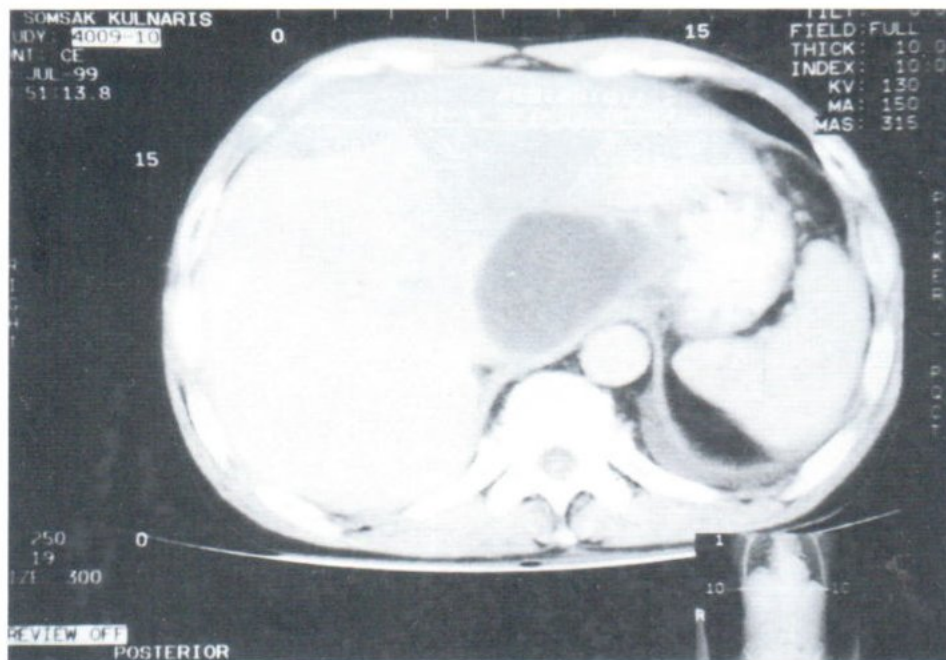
CT scan with IV contrast enhancement, there is well defined border mass at superior recess of omental bursa.
